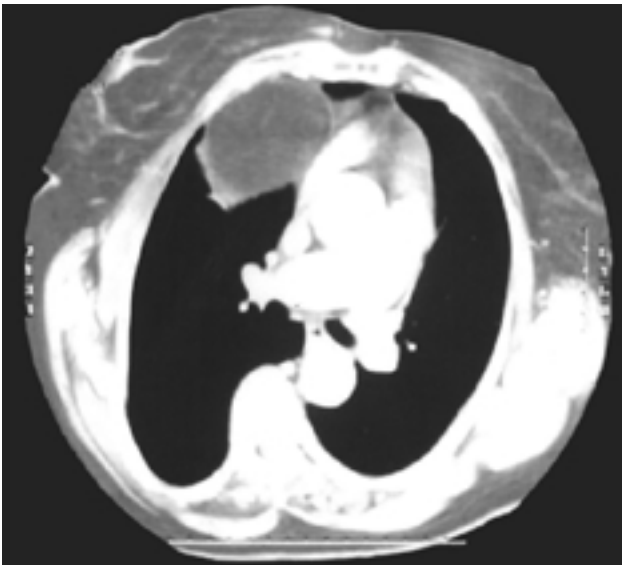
The lesion was observed anteromedially, starting parasternally and extending over to the carina, with an opacity which had the characteristics of fat tissue, and also pushing cardiac structures to the left hemithorax
